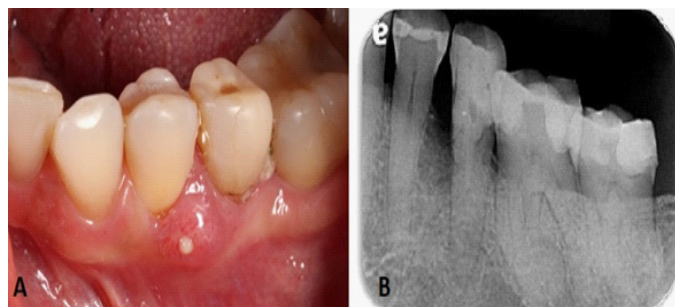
(A) Initial clinical image. (B) Initial periapical radiographic image.
